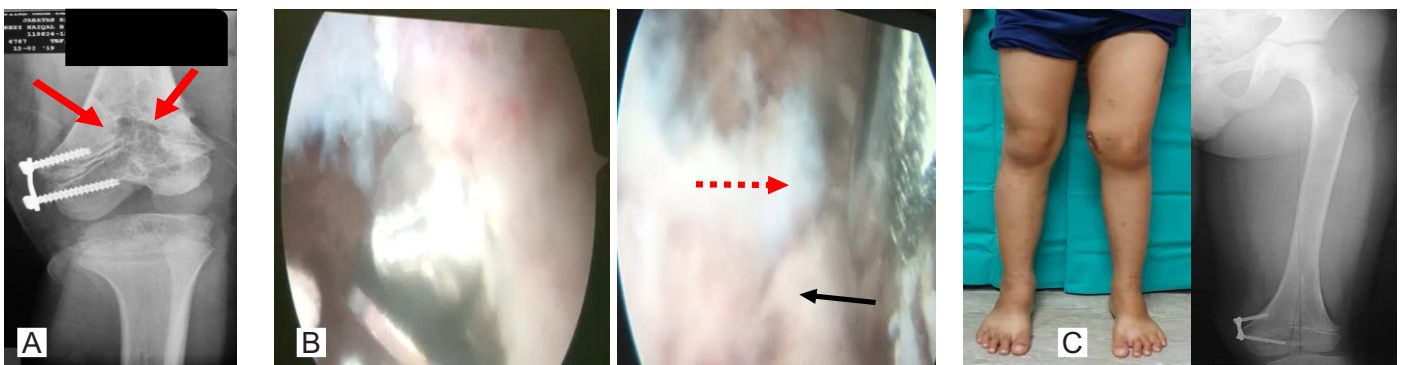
(A) Radiograph of the left knee after the endoscopic physeal bar excision and guided growth of the distal femur using plate. The red arrows showed the direction of the scope at the medial and lateral aspect of the femur for viewing and working portals. (B) Intraoperative images during the procedure. Curette and high speed were used to remove the physeal bar. Dotted red arrow indicates the normal look of the physis (white in color) and the black arrow showed the physeal bar (yellow in color). (C) The front view of the bilateral legs and anteroposterior radiograph of the left femur taken 2 years after the physeal bar excision and plating of the distal femur showed improvement of the valgus deformity and lateral distal femoral angle (78 degrees). However, there was presence of 2.5 cm shortening of the left femur.
